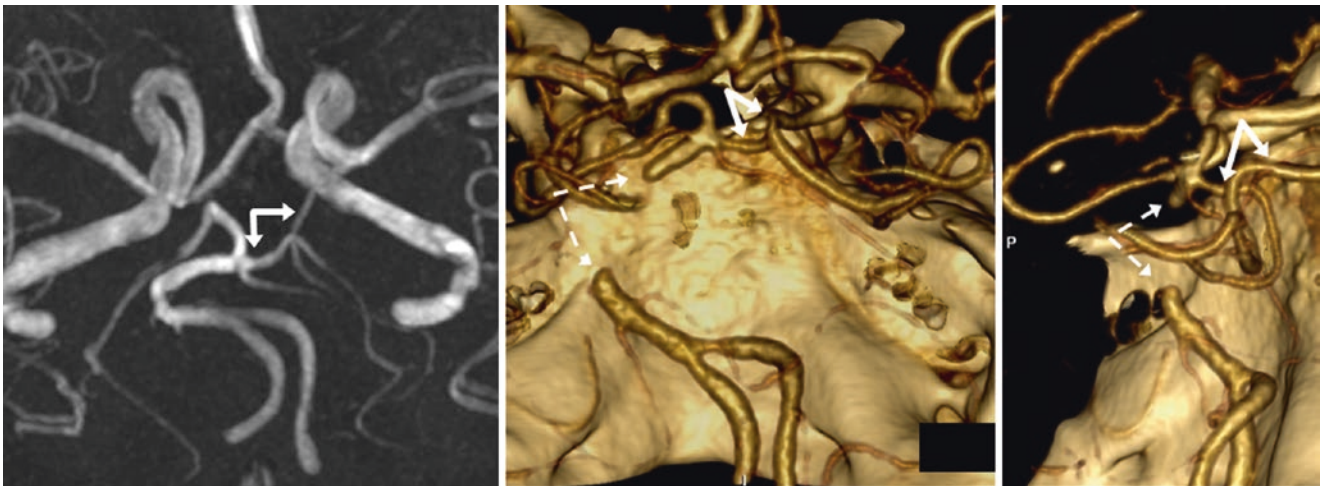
62-year-old with a duplicated right PCA (*solid arrows*) on a 3D TOF MRA superior view (*left*), and on 3D VR CTA PA (*middle*) and lateral (*right*) views, obtained 1 year after the MRA. Equally sized
